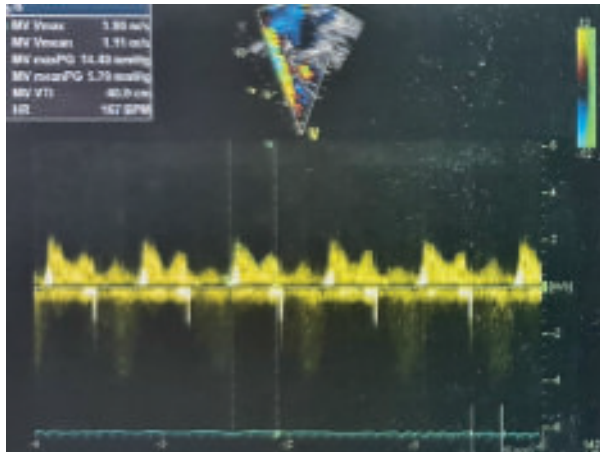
CW Doppler of mitral inflow of patient with Lutembacher's Syndrome
